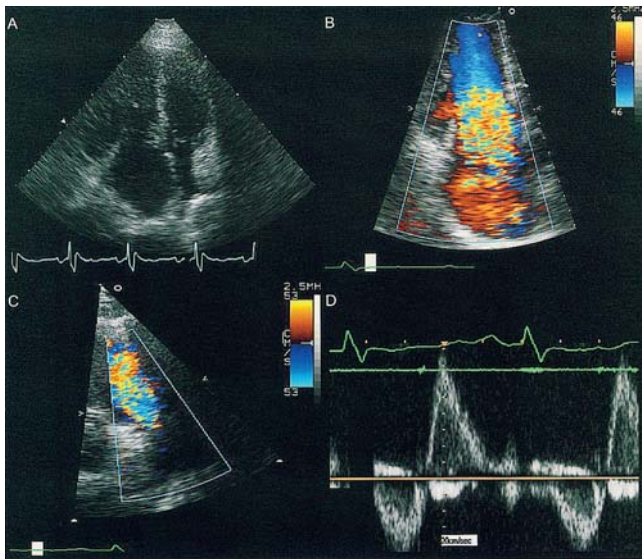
A) Two-dimensional image of the tricuspid valve from the apical four-chamber view in diastole, showing failure of the leaflets to coapt as a result of leaflet fibrosis and shortage. Note the relative enlargement of the right heart size compared to the left. B) Color flow Doppler across the tricuspid valve, demonstrating severe valve regurgitation (vena contracta 30 mm). C) Color flow Doppler across the pulmonary valve, demonstrating severe valve regurgitation (vena contracta 19 mm) (taken from the short-axis parasternal view of the right ventricular outflow tract). D) Pulsed-wave Doppler of the pulmonary valve, demonstrating laminar flow of the forward and backward flow across the valve consistent with severe pulmonary regurgitation. Note the pressure equalization between the pulmonary artery and right ventricle in mid diastole (vertical scale 20 cm/s velocity).
